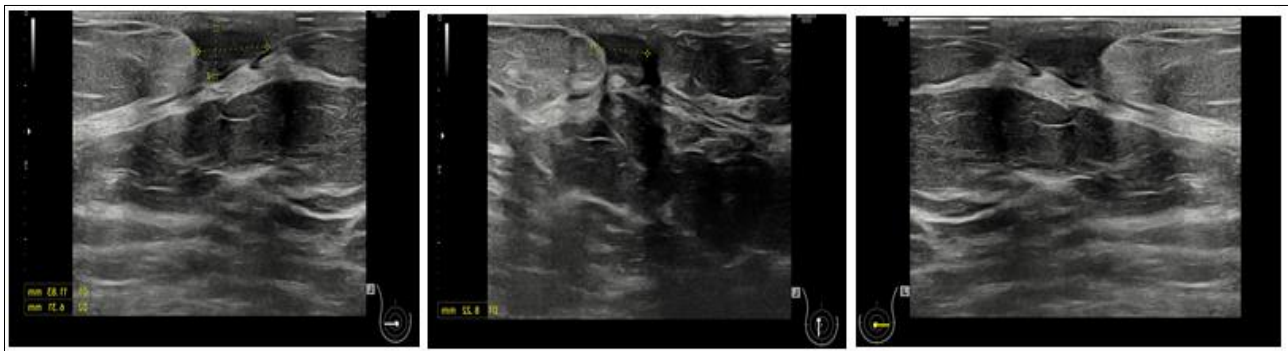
Ultrasound of the left breast demonstrating a small recurrent abscess measuring 12 × 6 mm.
